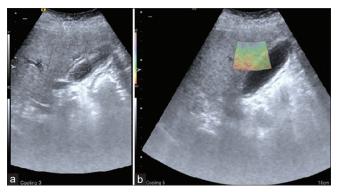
(a) Ultrasound image with gallbladder calculus and sludge with 4.5-mm thick wall. (b) VTI image at fundus with no adhesions with adhesions at the body. VTI: Virtual touch imaging
